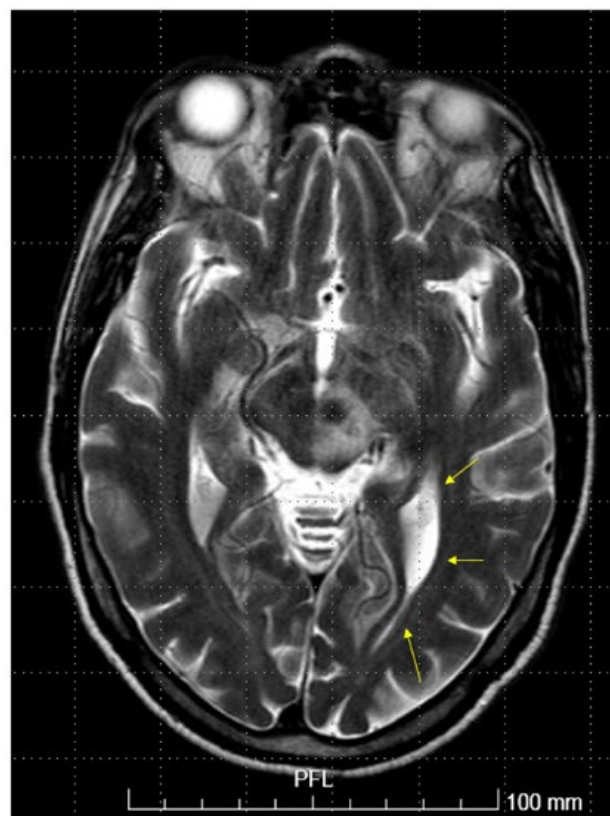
Extensive T2/FLAIR hypersignal in the posterior aspect of the inner capsule, thalamus, corona radiata at brain MRI.
